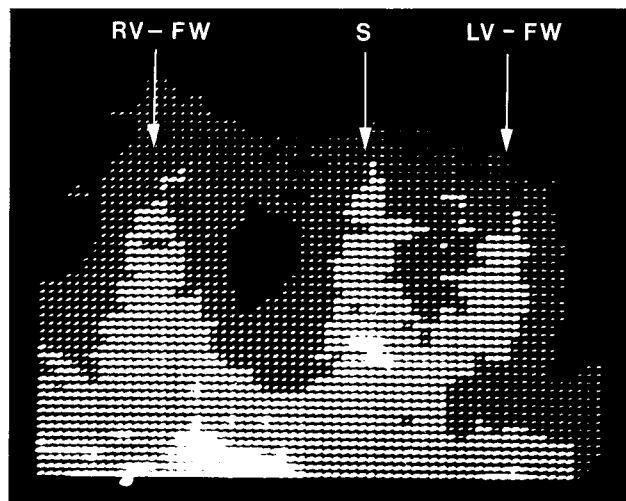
Thallium-201 scintigram (45° LAO projection) of a 36 year-old patient with atrial septal defect and 55% left-right shunt and normal pulmonary arterial pressure. (RV-FW = right ventricular free wall, S = septum, LV-FW = left ventricular free wall.)
